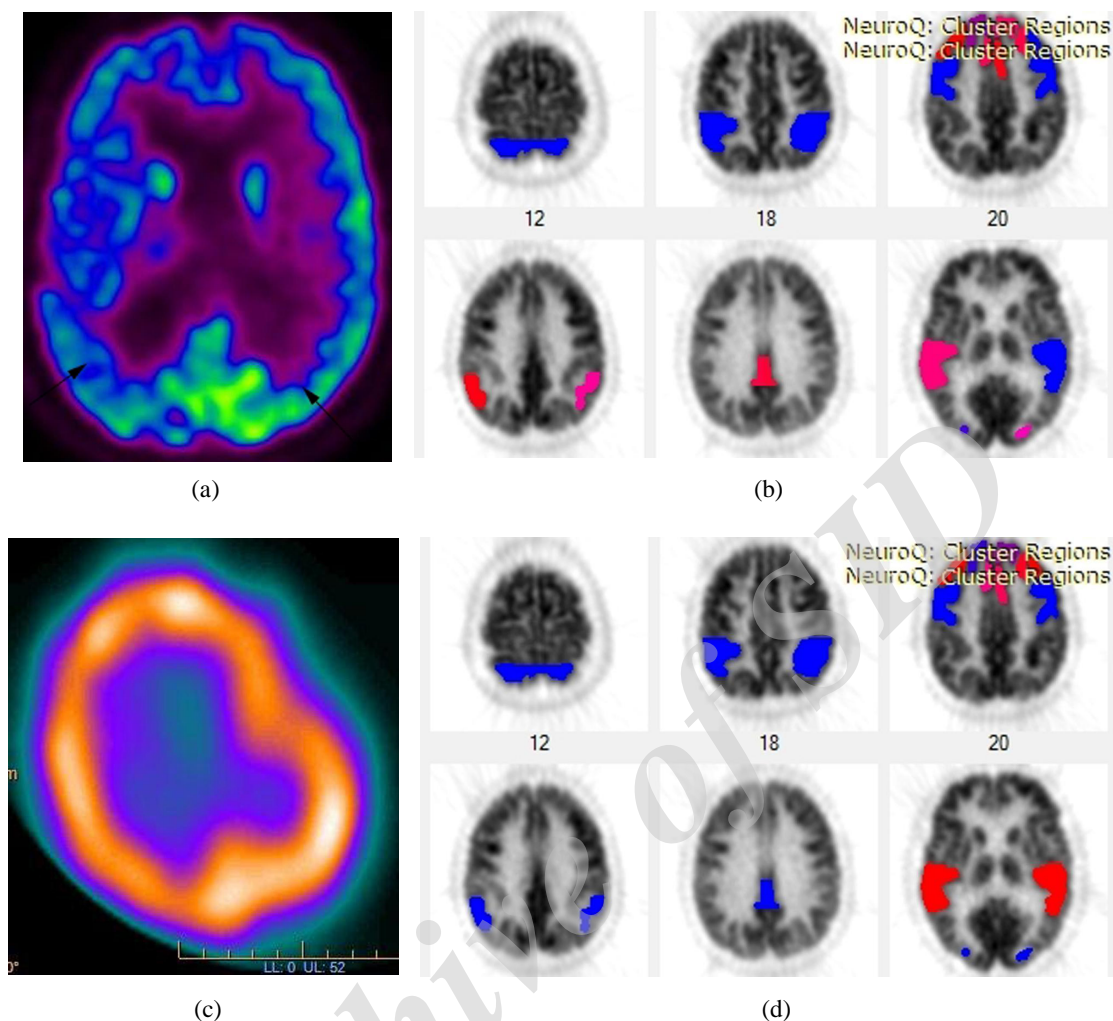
¹⁸F-FDG PET axial colored image (a) showing decreased ¹⁸F-FDG uptake in both posterior parietal (PP) and posterior cingulate nuclei (PCN) more to the right side, Neuro Q analysis colored image (b) showed hypometabolism in the right PP regions as well as the PCN (red colored and arrowed) < 3 SD, and <2 SD on the left PP (purple colored) (c) ^{99m}Tc-HMPAO SPECT axial image showing no hypoperfused zones in the PP and PCN (d) Neuro Q analysis colored image showing no hypoperfused zones (blue colored).
